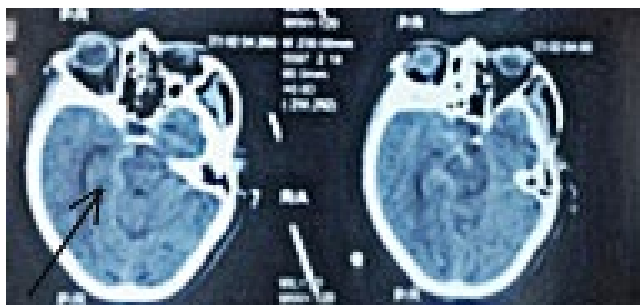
Plain CT (post-bleed) showing hyperdensity in subarachnoid space suggestive of SAH (arrow)
